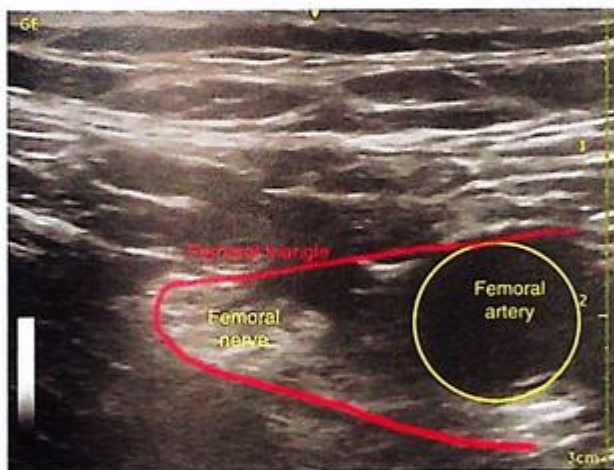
Ultrasound still of the anatomy of femoral block.
